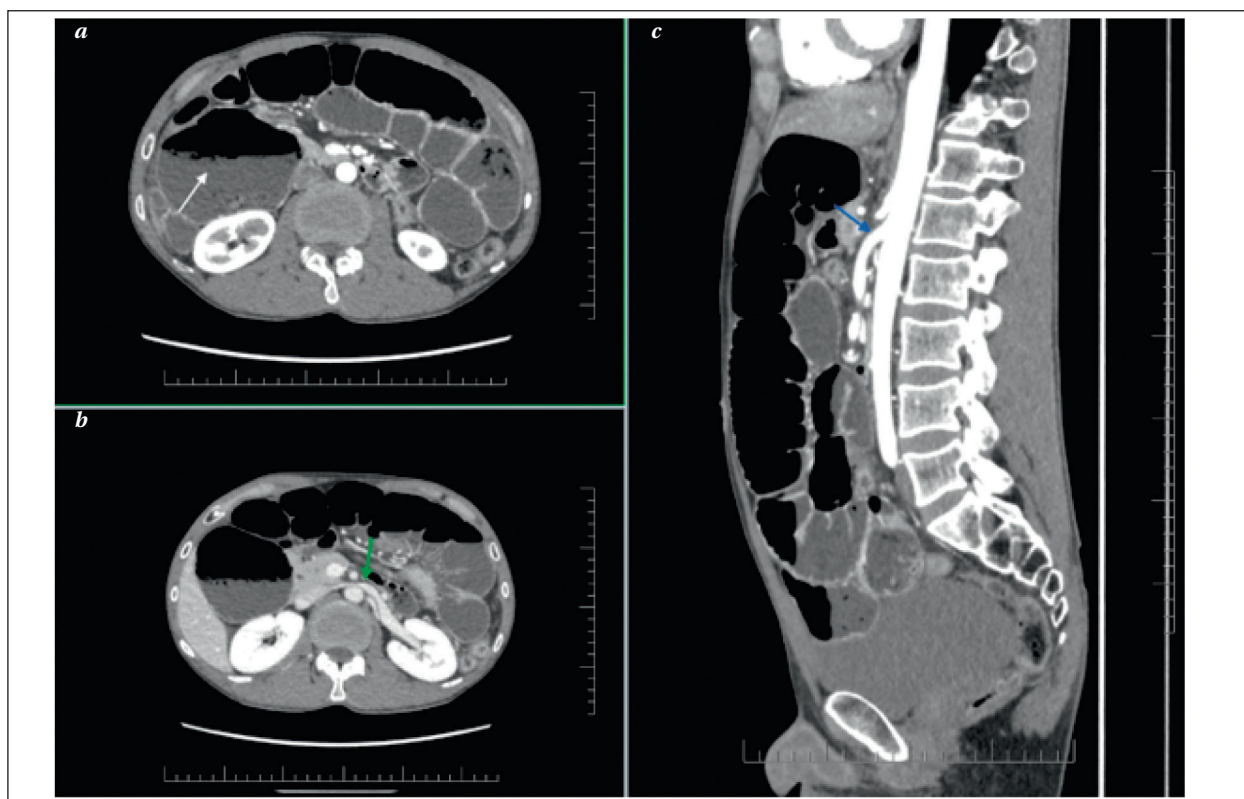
CT findings in SMA syndrome with concurrent nutcracker phenomenon.
